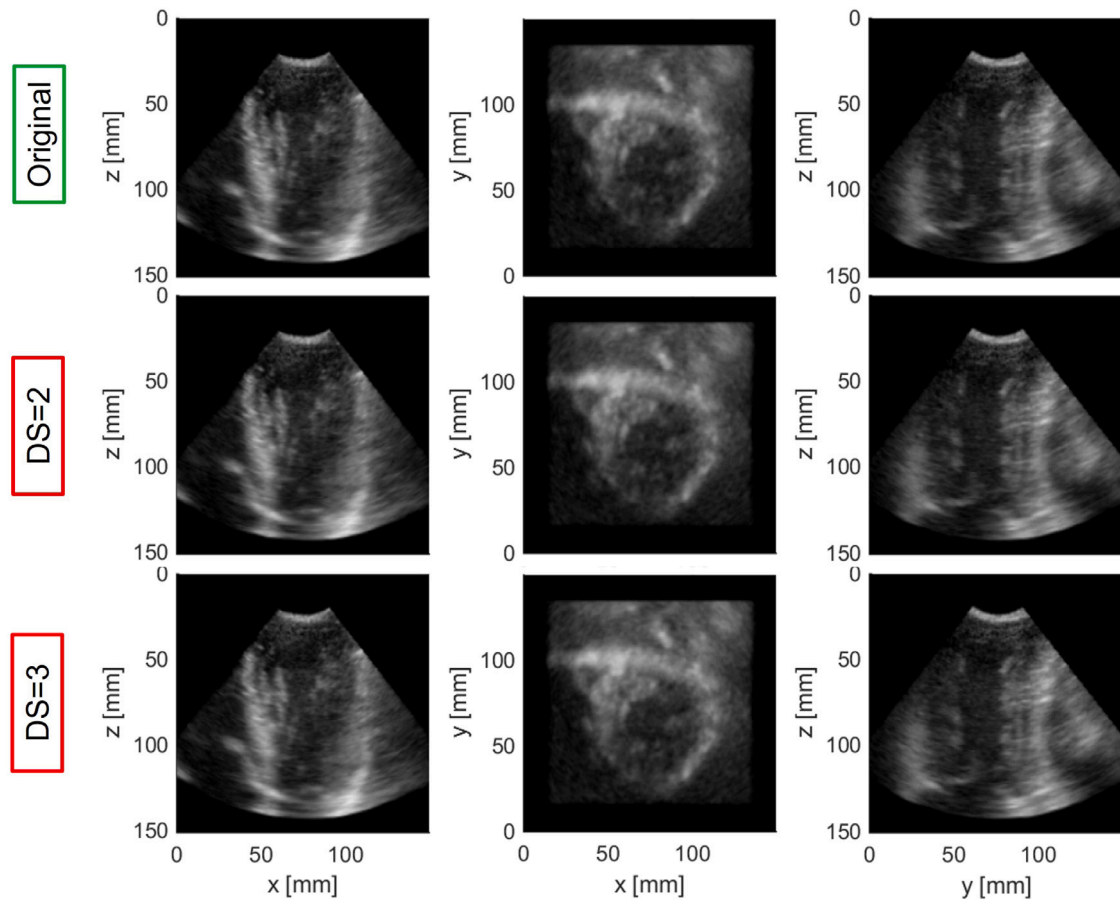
A 3D echocardiographic frame (Frame#20) reconstructed using our proposed technique at different DS rates (DATASET 3). The first, second, and third columns show this frame from different views in 'x-z', 'x-y', and 'y-z' coordinates, respectively (see the [link](#) to the original and reconstructed videos).
